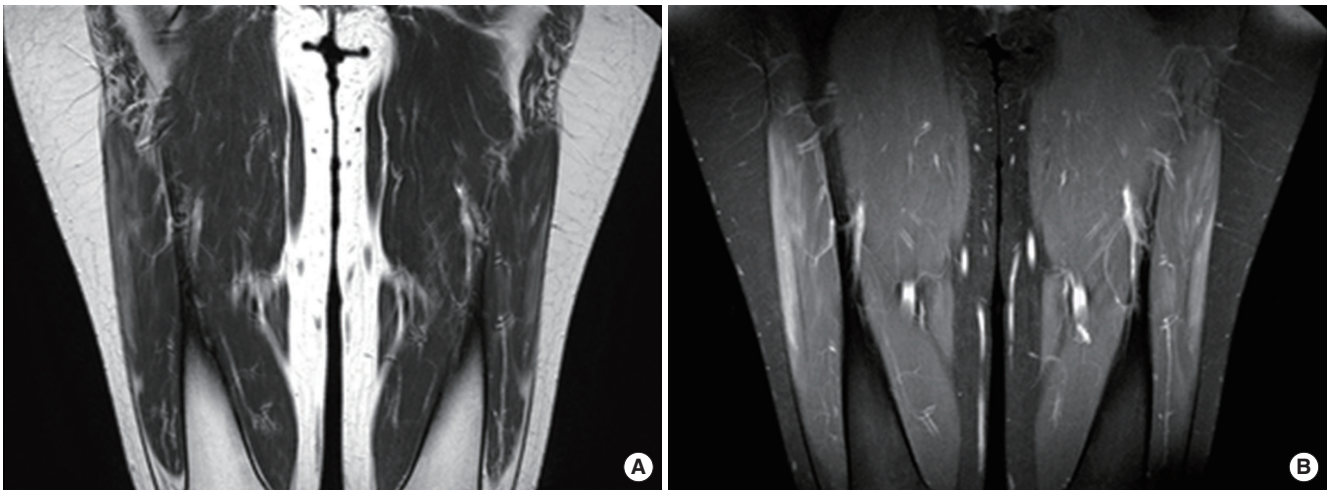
Coronal section of both thigh magnetic resonance imaging showed symmetrical increased signal intensity on both vastus lateralis muscles; more prominently observed in (B) fat suppressed T1 weighted image than (A) T1 weighted image.
